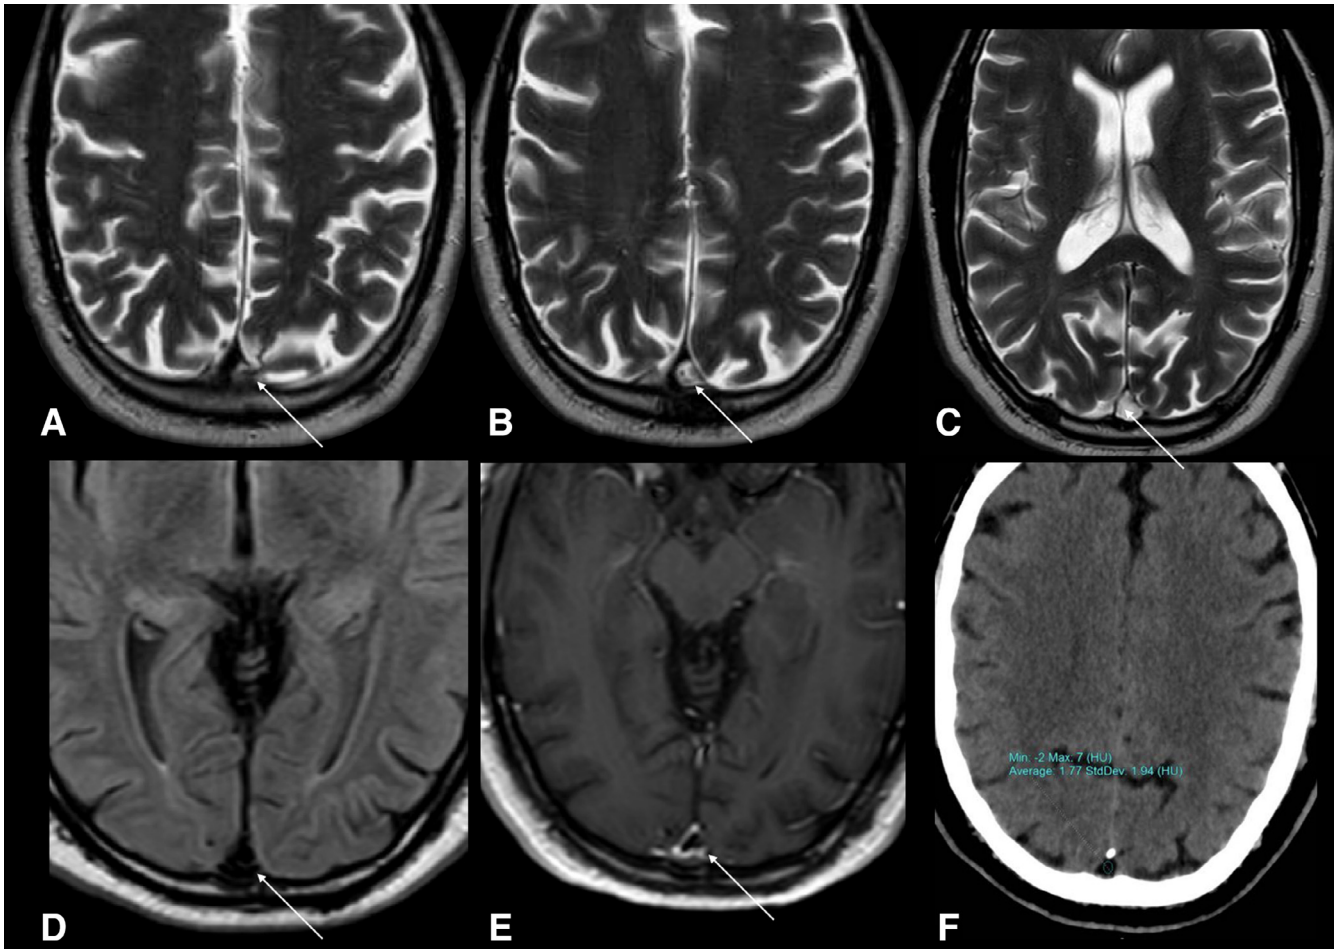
Top row: T2-weighted axial slices, ordered craniocaudally, demonstrating normal flow void in the superior sagittal sinus above the lesion (A), vascular pedicle of the arachnoid granulation entering the sinus (A and B), and CSF-isointense arachnoid granulation (C) obliterating any appreciable flow void within the superior sagittal sinus. Bottom row: T2-weighted FLAIR (D) shows suppression of signal similar to CSF, and postcontrast T1-weighted imaging (E) shows a nonenhancing T1-hypointense filling defect. Axial noncontrast CT (F) demonstrates CT density similar to CSF.
